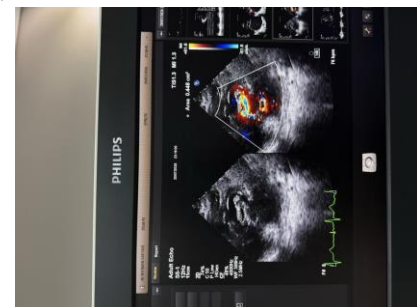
Two-dimensional echocardiographic planimetry demonstrating a severely reduced mitral valve area of 0.45 cm².
